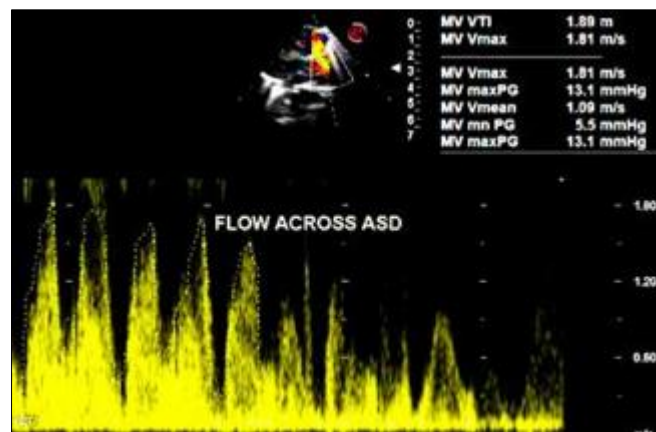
Pulse wave doppler (PWD) analysis across ASD reveals a peak/ mean gradient of 13.1/5.5 mmhg, suggesting a restrictive ASD flow
